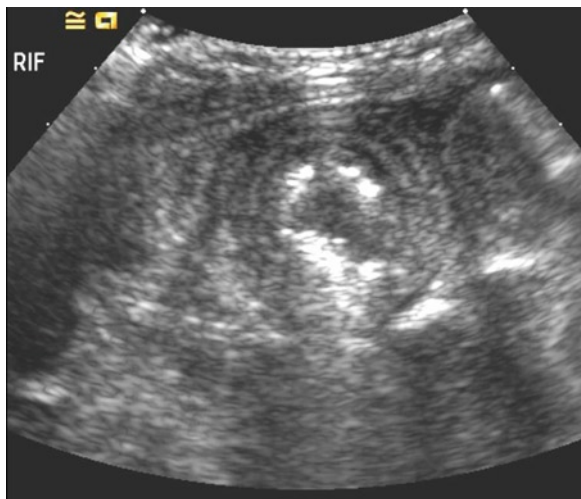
Ultrasound picture of intussusception.
